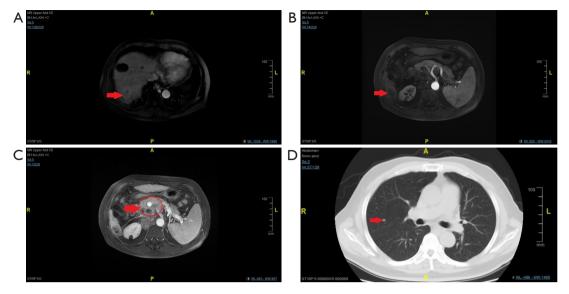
Contrast-enhanced abdominal MRI and chest CT on April 8, 2020. (A,B) Multiple active intrahepatic lesions (arrows). (C) Multiple retroperitoneal lymph node metastases (red circle). (D) Intrapulmonary metastasis (arrow). A, anterior; P, posterior; R, right; L, left; MRI, magnetic resonance imaging; CT, computed tomography.
